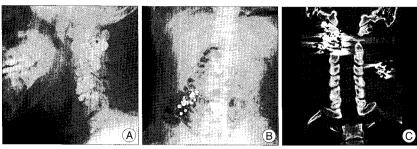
Preoperative radiologic findings. A: Cervical spine X-ray demonstrating radiopaque material on C1-2-3-4 level. B: Abdominal AP view showing radiopaque material on the middle abdomen, C: 3 dimensional reconstruction view of cervical computed tomography (CT) demonstrating C1-2-3 area radiopaque material in the spinal canal.
